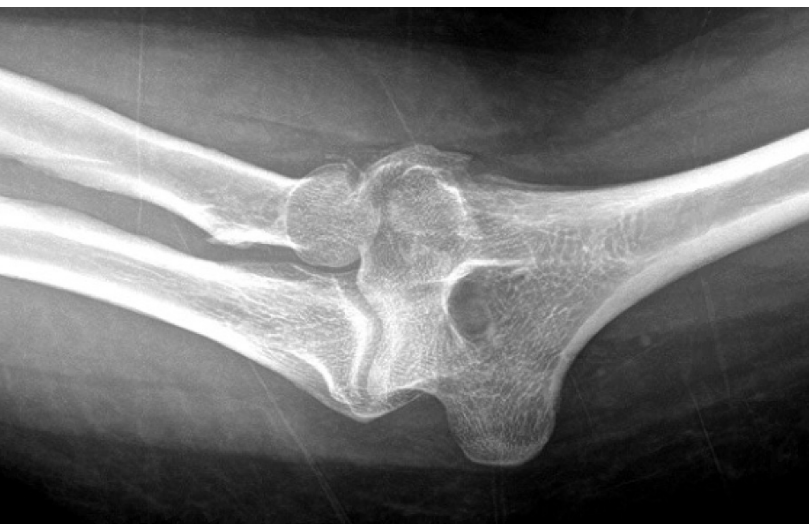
Anterior posterior radiograph showing displaced fracture of the capitellum and lateral condyle.
